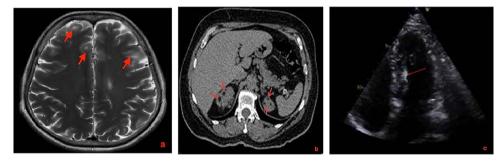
T2-weighted brain magnetic resonance imaging (PROPELLER): (a) hyperintense lesions with diffuse limits in the subcortical region of the bilateral frontal lobes suggestive of tubercles (red arrows). At the level of the periventricular white matter, hyperintense lines were observed bilaterally, extending toward the cortex and corresponding to the radial migration lines. (b) Simple transverse abdominal tomography image showing multiple hypodense renal lesions compatible with renal AMLs (red arrows). (c) Echocardiogram in the apical four-chamber projection: cardiac rhabdomyoma: a homogeneous hyperechoic nodular mass with well-defined contours of 6 x 9 mm (red arrow) is observed in the interventricular septum, which protrudes intracavitarily without generating an obstruction gradient.
